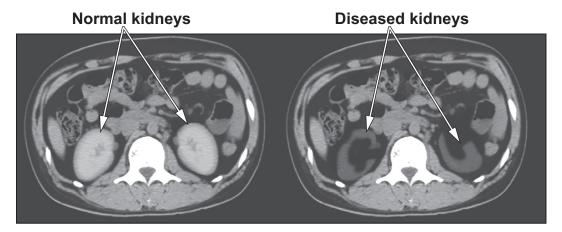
CT scans of normal and diseased kidneys.
